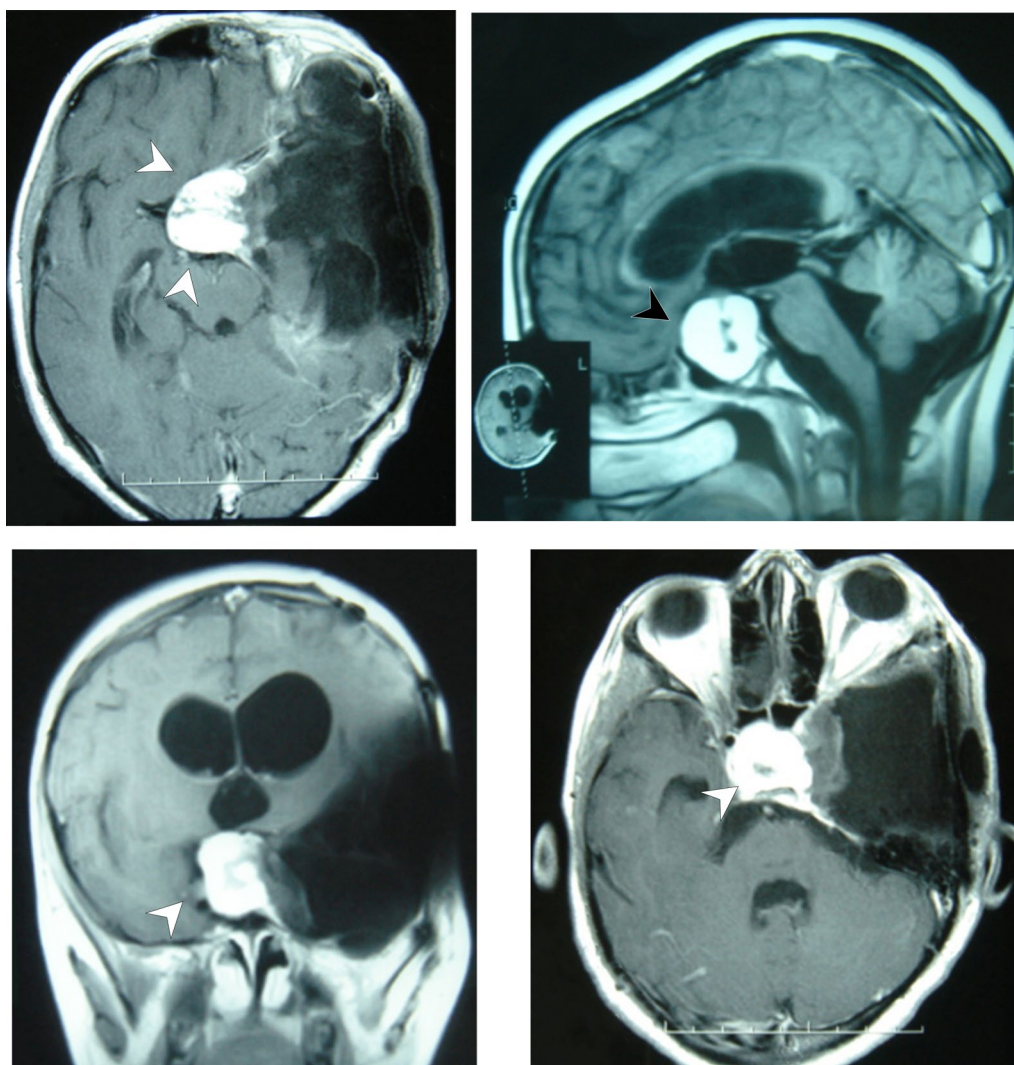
Postoperative magnetic resonance imaging scans of the patient years after the surgical intervention. The residual mass (arrowheads) did not expand beyond what is shown here
